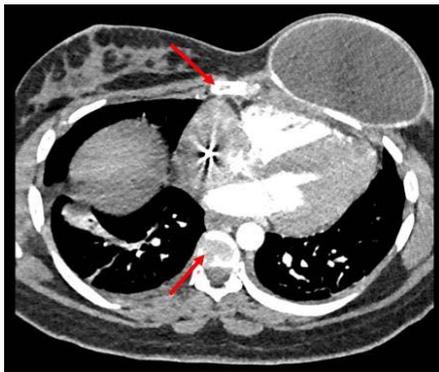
Chest CT at 21wks showing diffuse lytic lesions in vertebral bodies and sternum.
